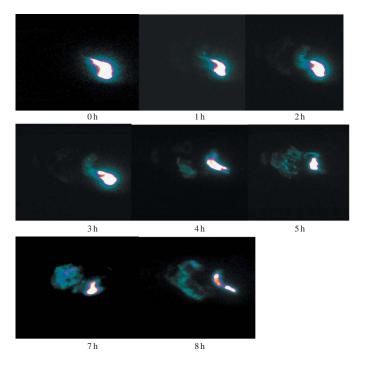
Gamma scintigraphic images of ion-exchange fiber in fed volunteers.
